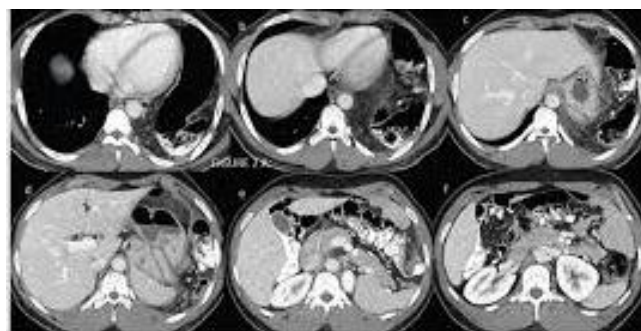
Computer Tomography (CT) Scan: images of a defect in the posterior left diaphragm and herniation of intra-abdominal fat and small bowel into the left hemithorax
